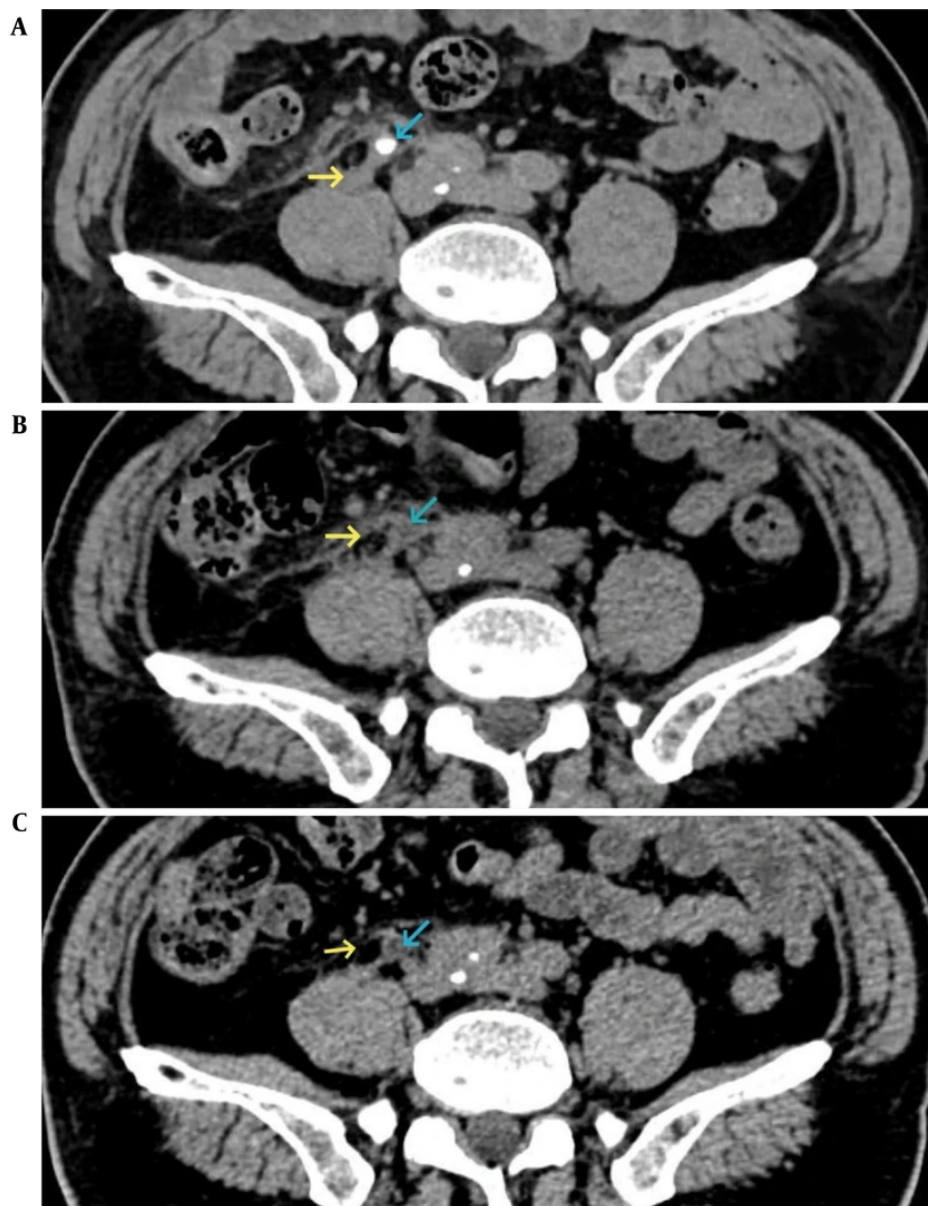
A, CT urography (2025 - 02 - 24): Prominent periureteral stranding is noted. B, CT scan (2025 - 03 - 06): Mild resolution of periureteral stranding is noted. C, CT scan (2025 - 04 - 14): The periureteral stranding has completely resolved (blue arrow: ureter; yellow arrow: periureteral stranding).
